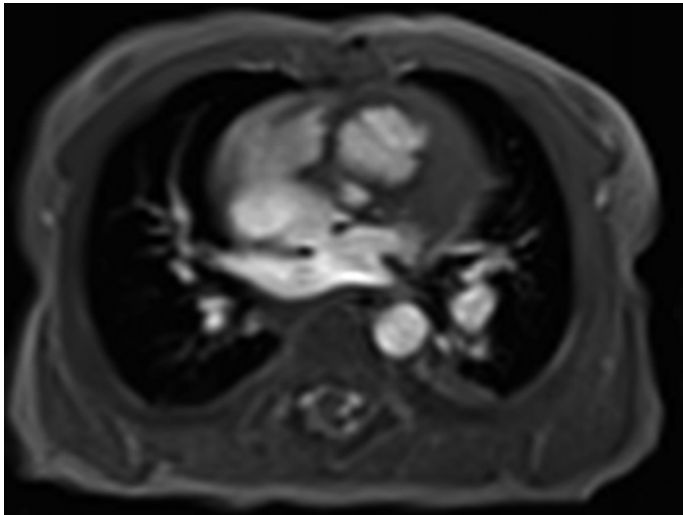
Magnetic resonance imaging (MRI) to analyze pulmonary vein morphology or aortic arch malformations
